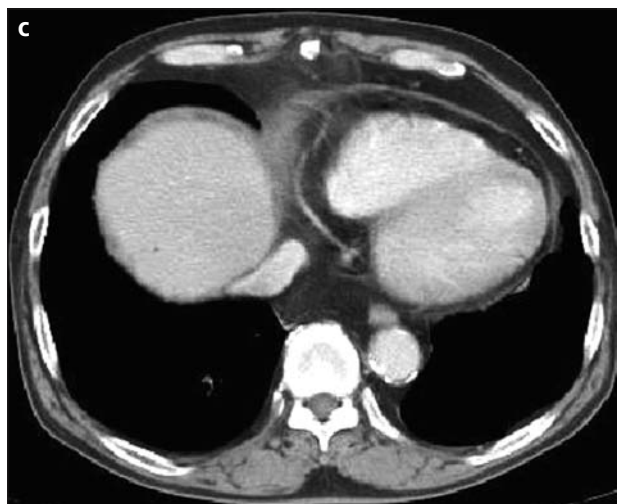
Contrast-enhanced axial CT image shows a heterogeneously enhanced mass with an irregular margin in the right cardiophrenic angle, immediately adjacent to the right aspect of the pericardium and the superior aspect of the dome of the right hemidiaphragm. It was thought to be an invasive malignancy. A small pericardial effusion is also seen.
